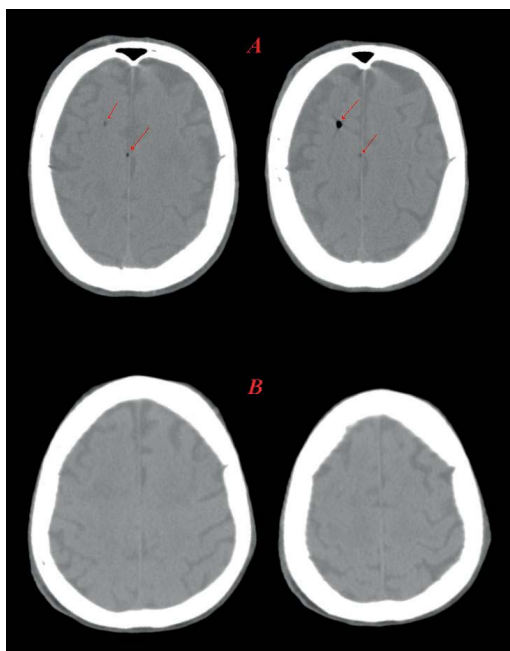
a) Right frontal subarachnoid air bubbles showed by computed tomography scans early after an uneventful fibrobronchoscopy. b) Complete resolution of the cerebral air embolism after hyperbaric therapy.
